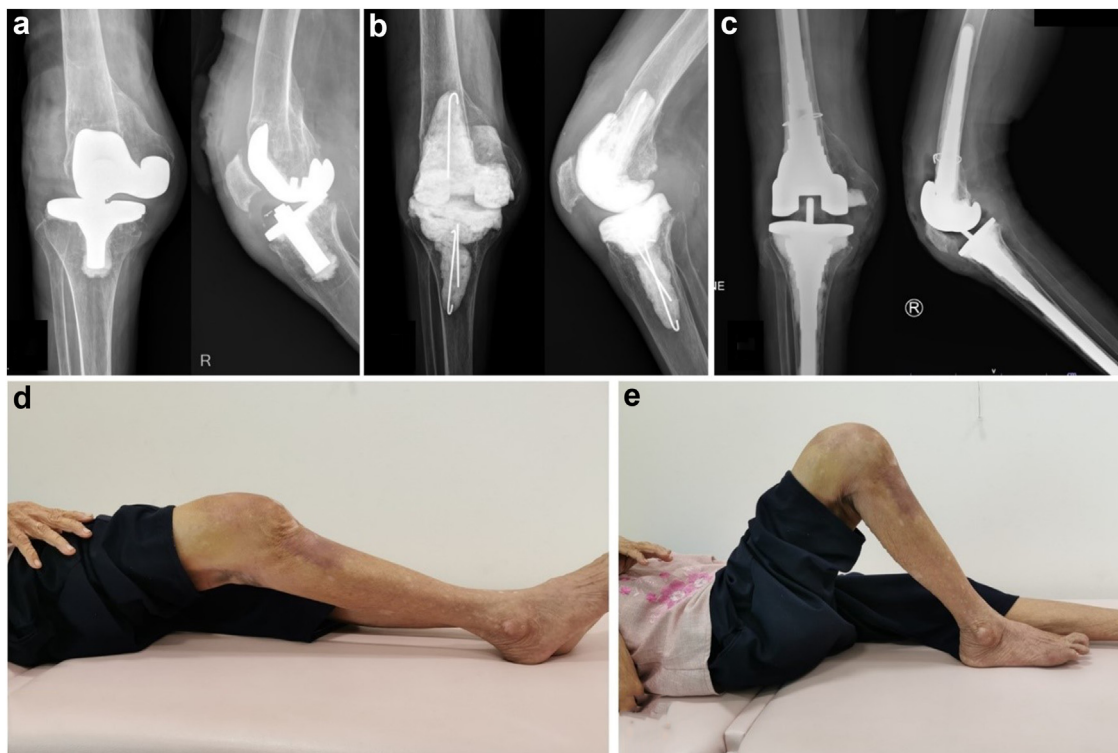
Radiographs (a) before the first-stage surgery, (b) showing the spacer condition before reimplantation, and (c) after reimplantation. Range of motion of the knee before the preoperative second-stage surgery: (d) flexion, (e) extension.
